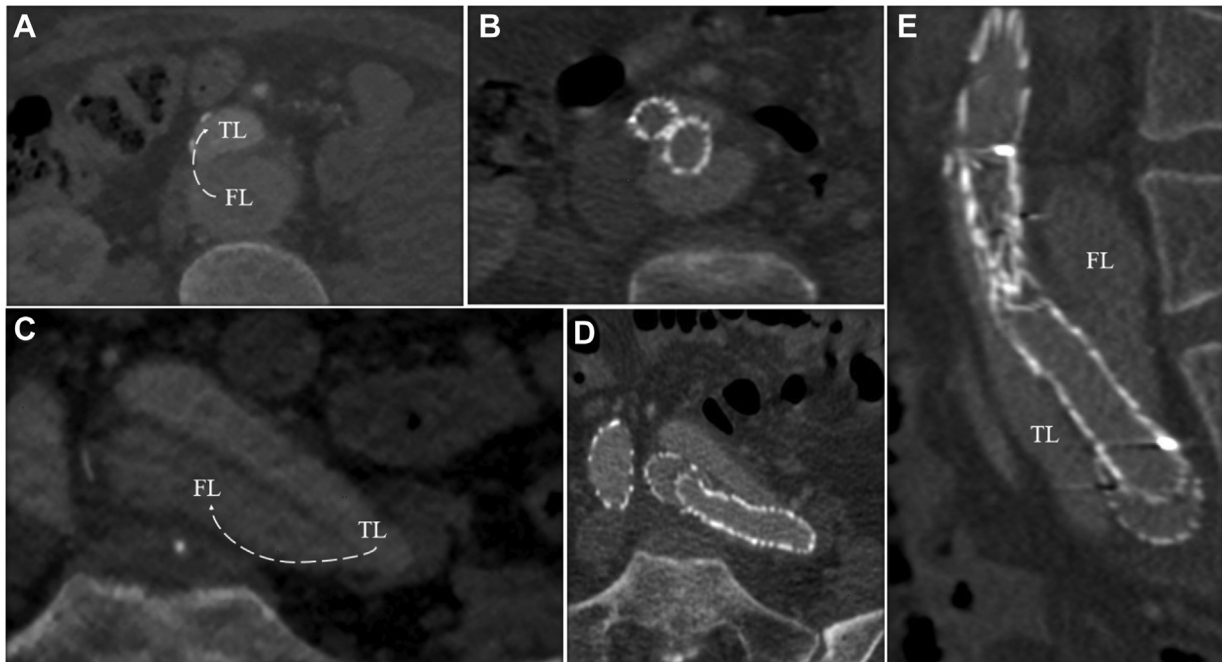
Preoperative (A and C) and respective postoperative (B, D, E) computed tomography angiographies (CTAs) depicting the perfusion of the false lumen (FL) through the true lumen (TL).
